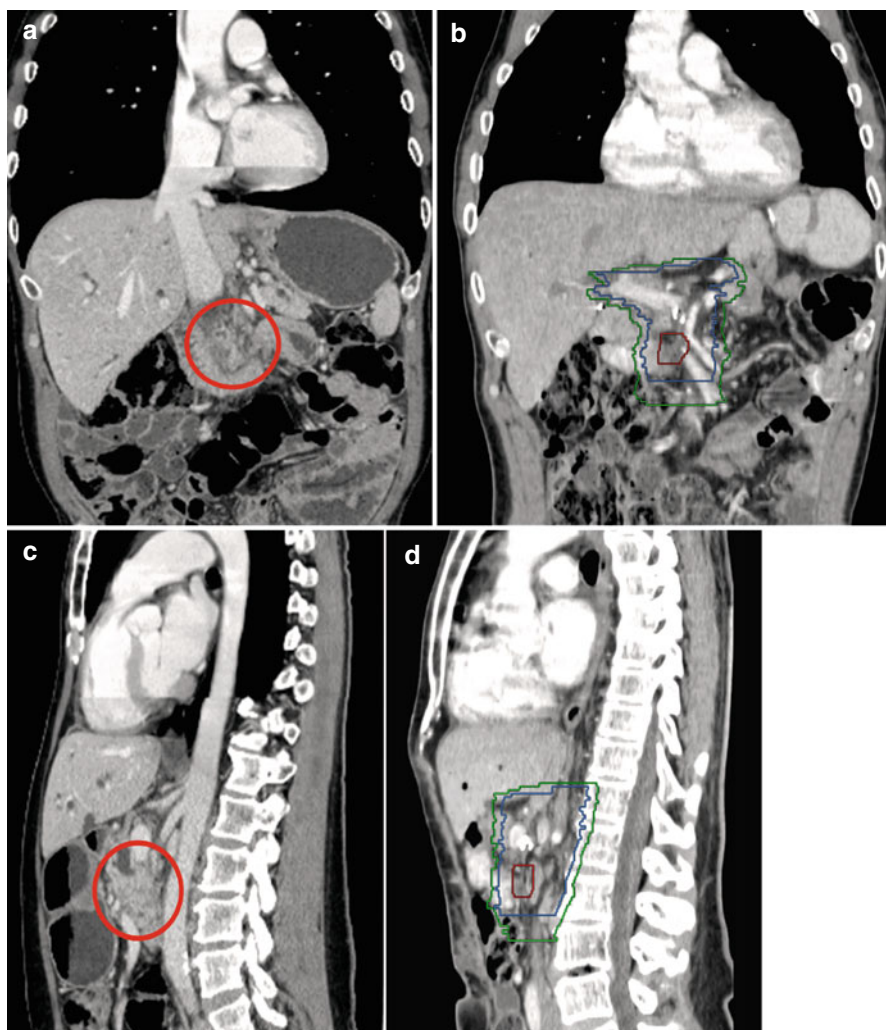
Postoperative case; example of a low-lying tumor. A patient with pT3N1 resected pancreatic adenocarcinoma with a 2.3-cm lesion in the head/uncinate, close <1-mm margins posteriorly and inferiorly, and 14/25 nodes positive for involvement. (a) Coronal preoperative CT with tumor marked in red; (b) coronal planning images with PTV in green, CTV in blue, and postoperative bed in red; (c) sagittal preoperative CT with tumor marked in red; (d) sagittal planning images with PTV in green, CTV in blue, and postoperative bed in red; (e) axial preoperative CT with tumor marked in red; (f–h) axial planning images with PTV in green, CTV in blue, and postoperative bed in red
